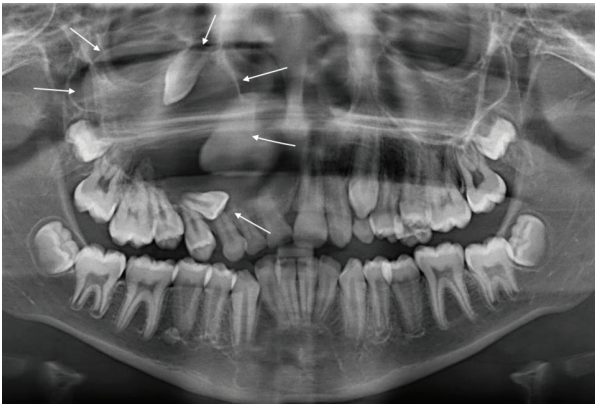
Panoramic X-Ray Imaging of Cyst
